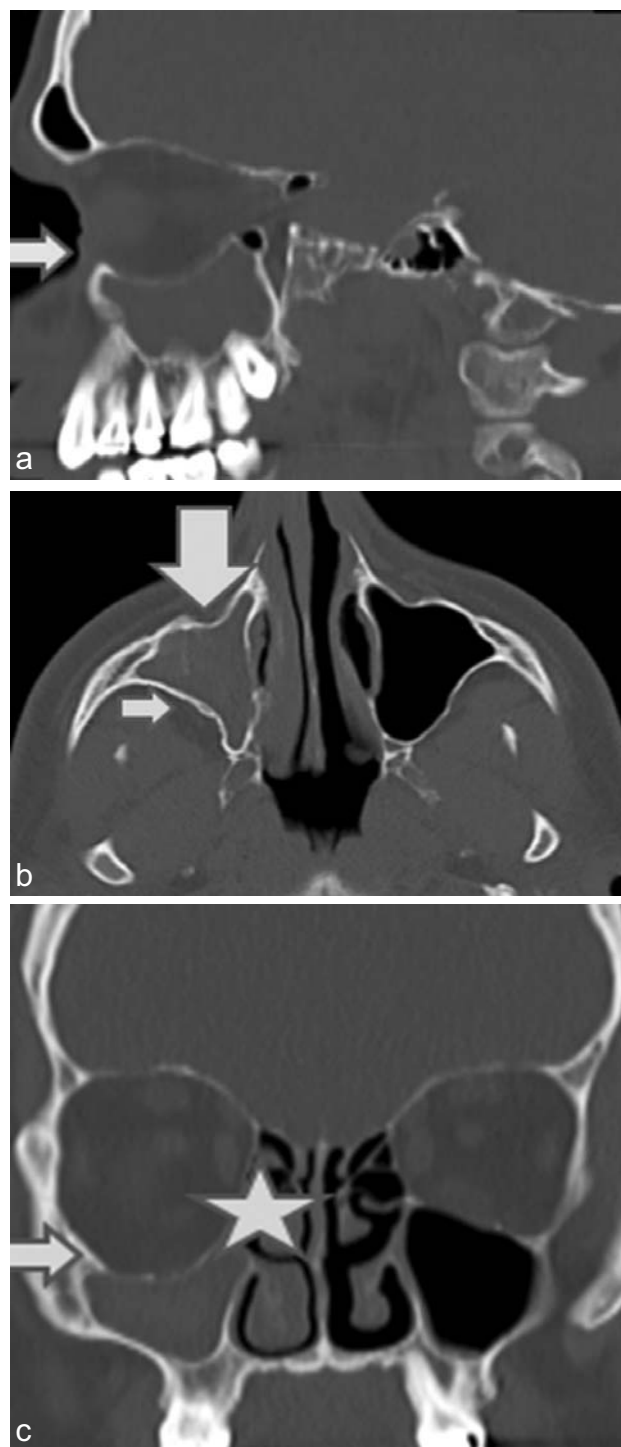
(a,b,c): CT paranasal sinuses. Sagittal (a), axial (b), and reconstructed coronal (c) images demonstrate a fully formed but contracted right maxillary sinus that is completely opacified with inward bowing of all four walls (arrows). There is inferior bowing of the roof (orbital floor) with increase in right orbital volume and enophthalmos. Posterior displacement of the anterior wall is marked by the thick downward arrow. The right ostiomeatal complex is occluded (star). The left maxillary sinus and remaining paranasal sinuses are normal.
